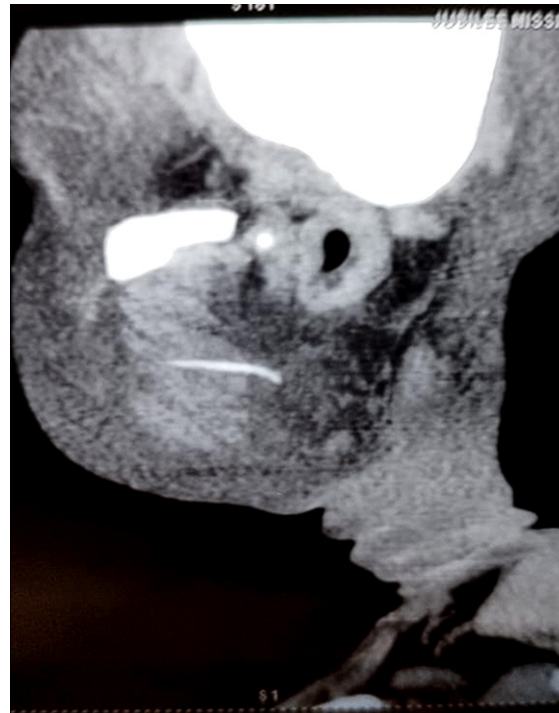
CT sagittal cut at parotid gland, showing linear hyperdense structure
